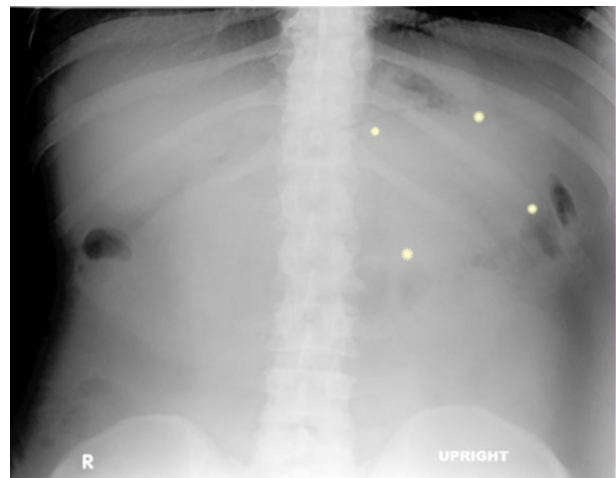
Upright plain film at the time of first admission. Although the image of the abdomen was unrevealing on initial read, later inspection identified the suggestion of increased gastrocolic separation in the left upper quadrant (region marked by stars). This separation between the stomach and the transverse colon is consistent with a fluid collection in the lesser sac.
